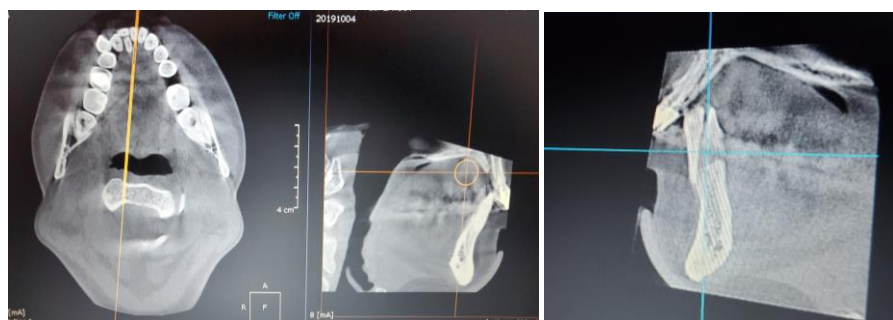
Selected images of CBCT to show the crowding of anterior mandibular teeth and the amount of alveolar bone
